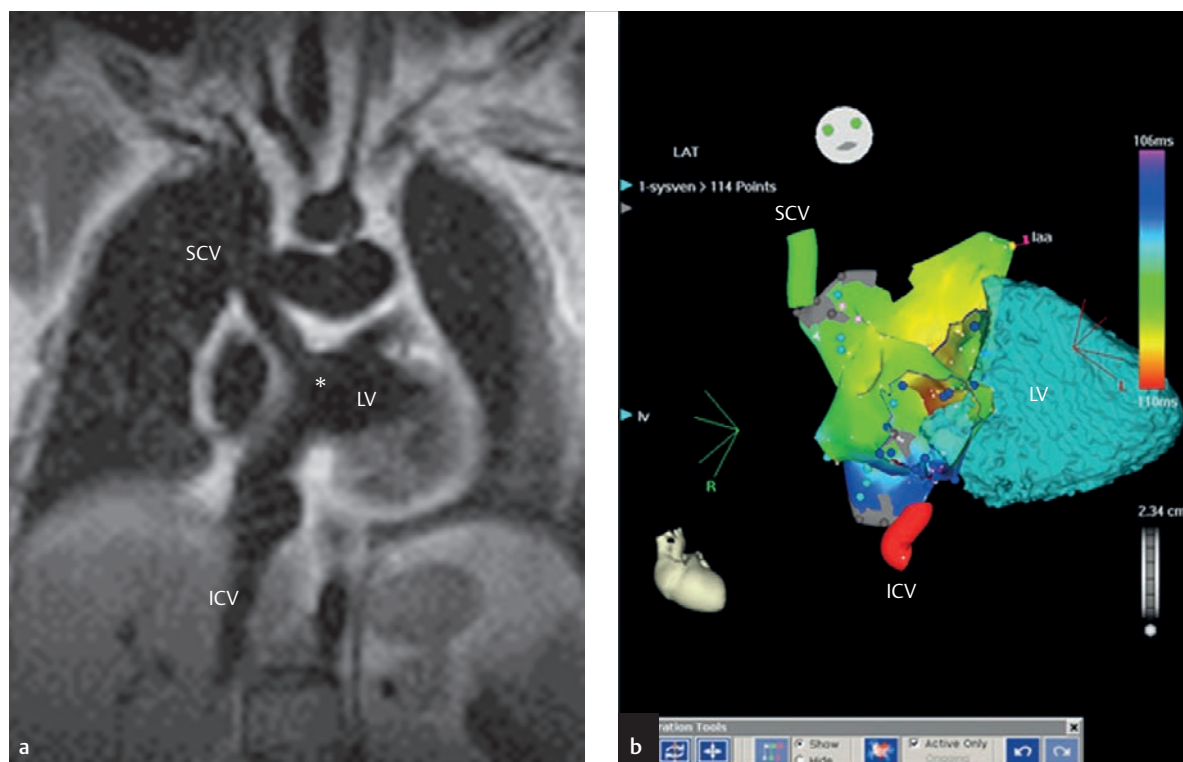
Imaging integration of MRI/CT data.
